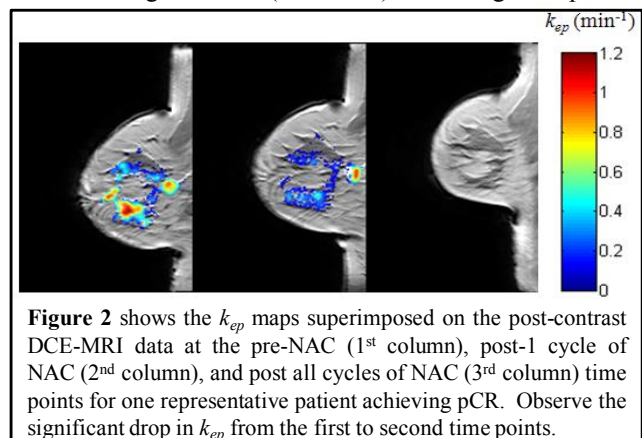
shows the k_{ep} maps superimposed on the post-contrast DCE-MRI data at the pre-NAC (1st column), post-1 cycle of NAC (2nd column), and post all cycles of NAC (3rd column) time points for one representative patient achieving pCR. Observe the significant drop in k_{ep} from the first to second time points.
